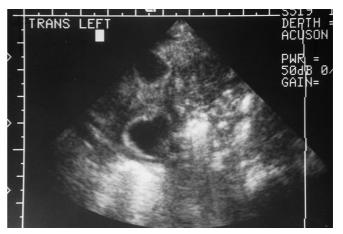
Abdominal ultrasound. A heterogenic, ill-defined mass was revealed between the left hepatic lobe, the pancreas and the splenic hilum. Within the mass two small round cystic masses were noted
